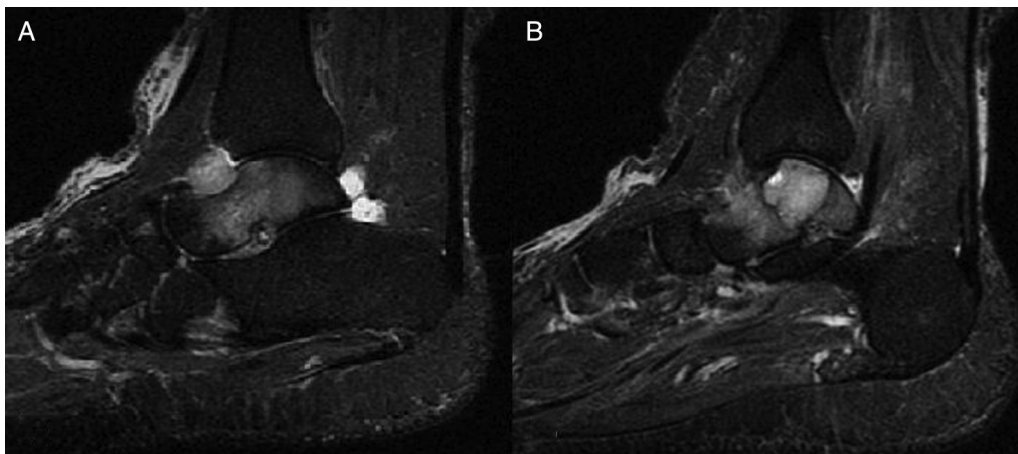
T₂-weighted sagittal magnetic resonance images demonstrating (A) a distinct intra-articular soft tissue mass with erosion into the talar cortex and (B) a separate cystic lesion of the talus with extensive surrounding edema.
